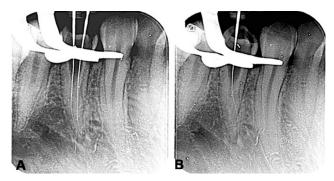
Radiographic images about root canal exploration A: buccal canals, B: lingual canal.
